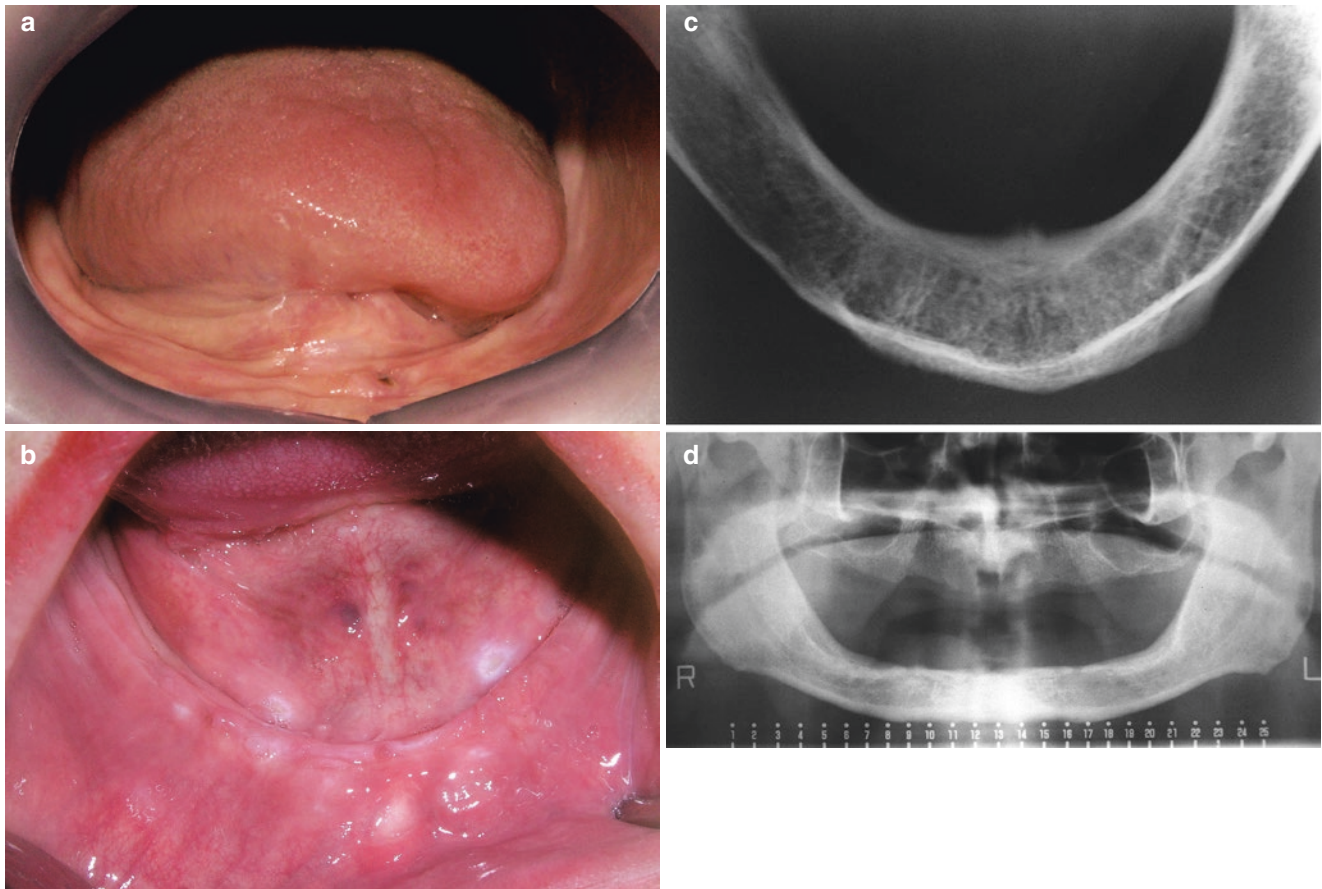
(a, b) Mandibular resorbed ridge. (c, d) Occlusal and panoramic x-rays
